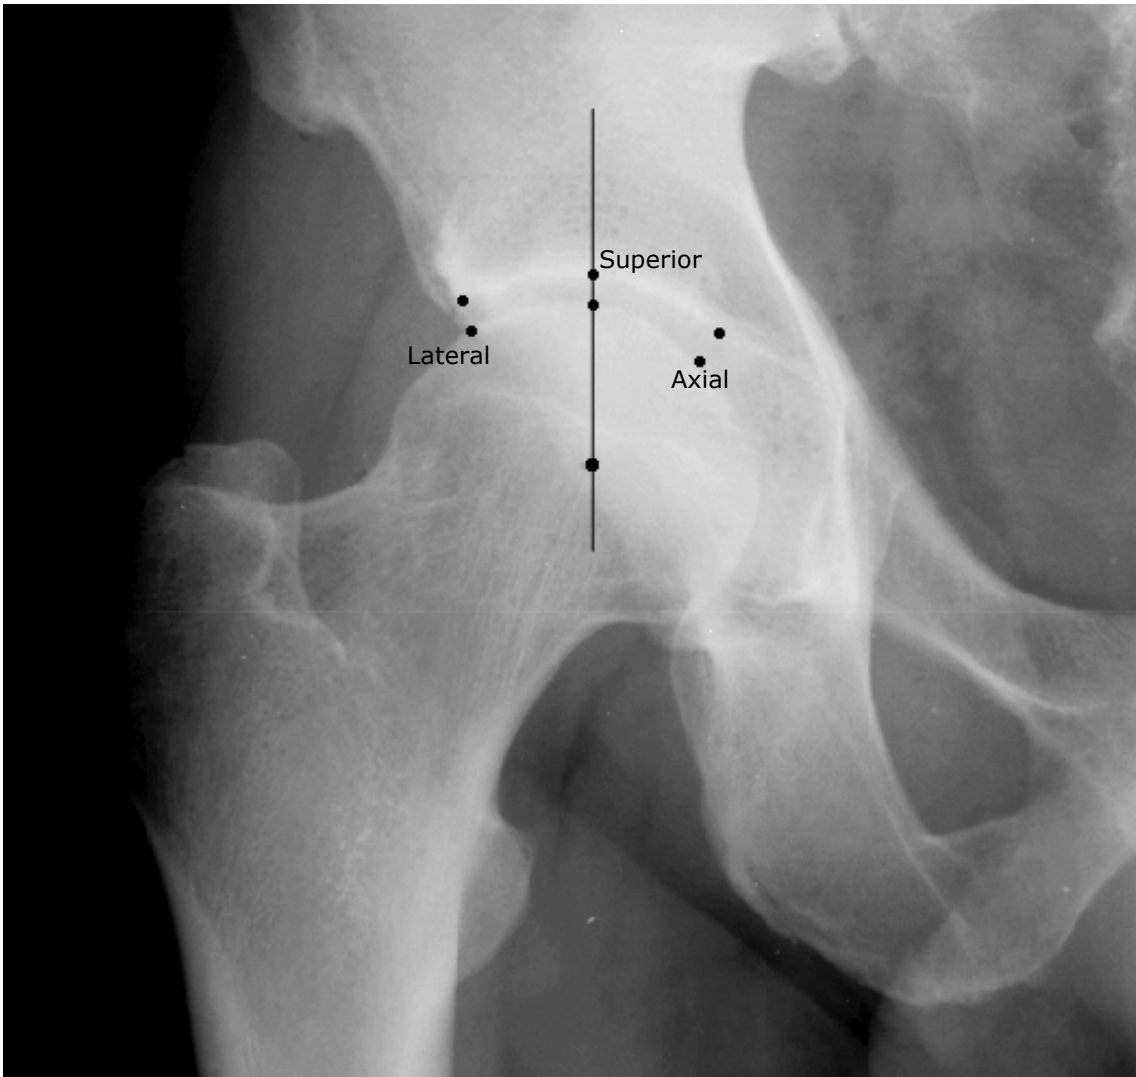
Radiograph of a hip joint with the points measured for JSW in the weight-bearing area indicated: Lateral, superior, and axial.
